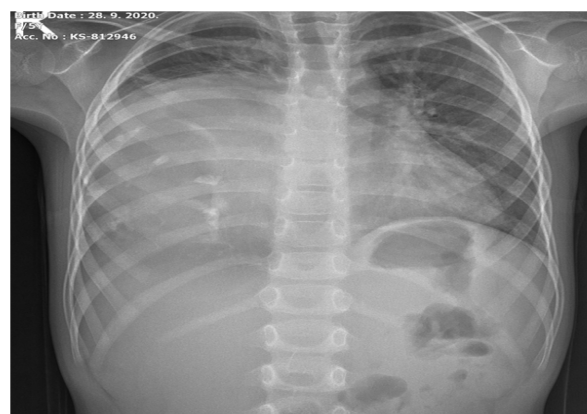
Chest radiograph showing opacification of the right hemithorax.
